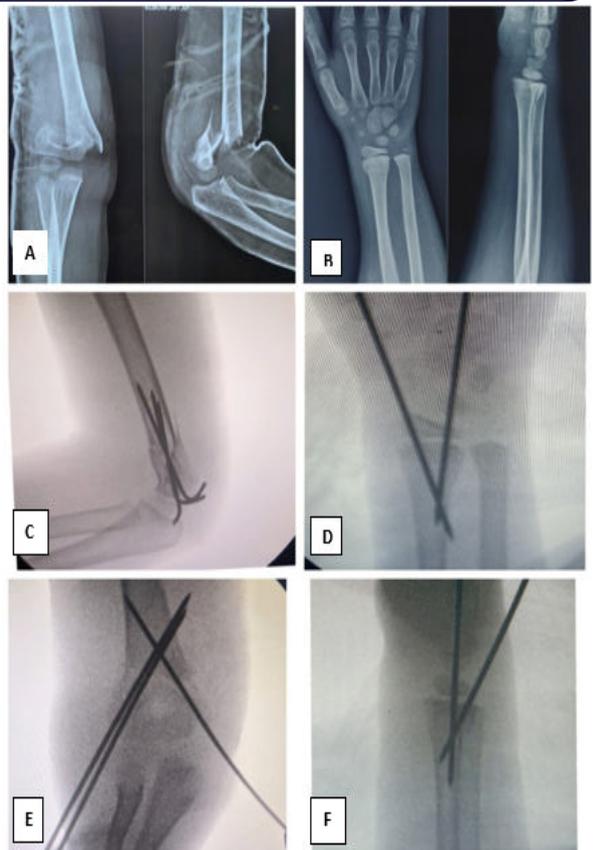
(A and B) - Depicts preoperative radiograph of right elbow and right wrist, (C and E) - Depicts Intraoperative fluoroscopic radiographs of right elbow and (D and F) - Depicts fluoroscopic intraoperative radiographs of right wrist.
